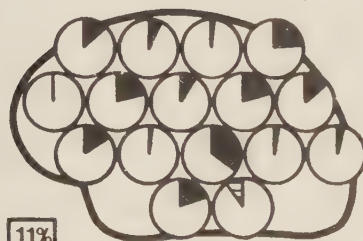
A case of right hemisphere multi-focal epilepsy, lesions verified by CT-scan. Numbers in boxes show asymmetry of mean hemispheric flows, clock symbols show regional flow asymmetries, all expressed as right flow divided by left flow (percent). Note the sharper asymmetry by FA, and the reversal of asymmetry in the anterior temporal area.
